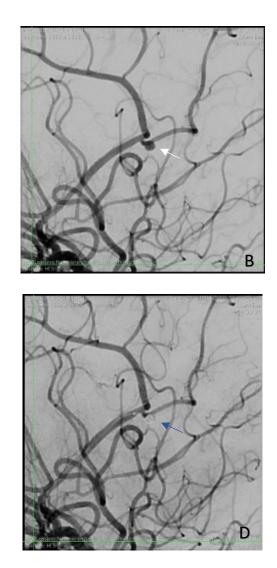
<u>Figure 2A</u>-CT showing SAH (black arrow). <u>Figure 2B</u> DSA showing right DACA aneurysm (white arrow) <u>Figura 2C</u>- DSA showing Saccular aneurysm of right DACA 3mm and one of the ipsilateral MCA 4 mm (black arrow shows the DACA aneurysm, red arrow shows the MCA aneurysm). <u>Figure 2D</u>- Optimal embolization of right DACA aneurysm (blue arrow).
